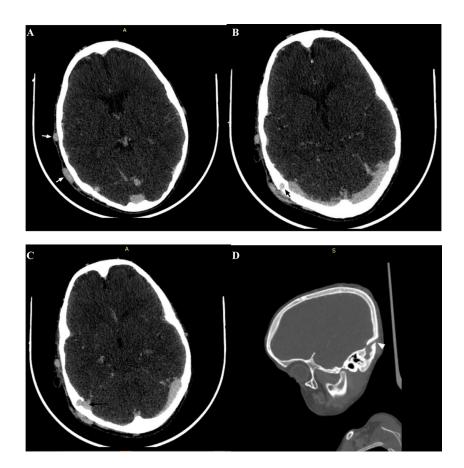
Axial angiographic (A–C) and sagittal bone window (D) postcontrast head and neck CT- Axial images (superior to inferior sections) show markedly dilated and tortuous right parito-temporo-occipital scalp vascular structures (white arrow) which communicate with the distal right transverse sinus through a prominent emissary vein within the right temporal bone (black arrows). No arterial feeder, nidus, or enhancing soft tissue lesion. No thrombosis of the dural venous sinuses or the dilated scalp venous channels. Sagittal bone windowed image better demonstrates the right temporal bone defect with sclerotic margin (white arrowhead).
